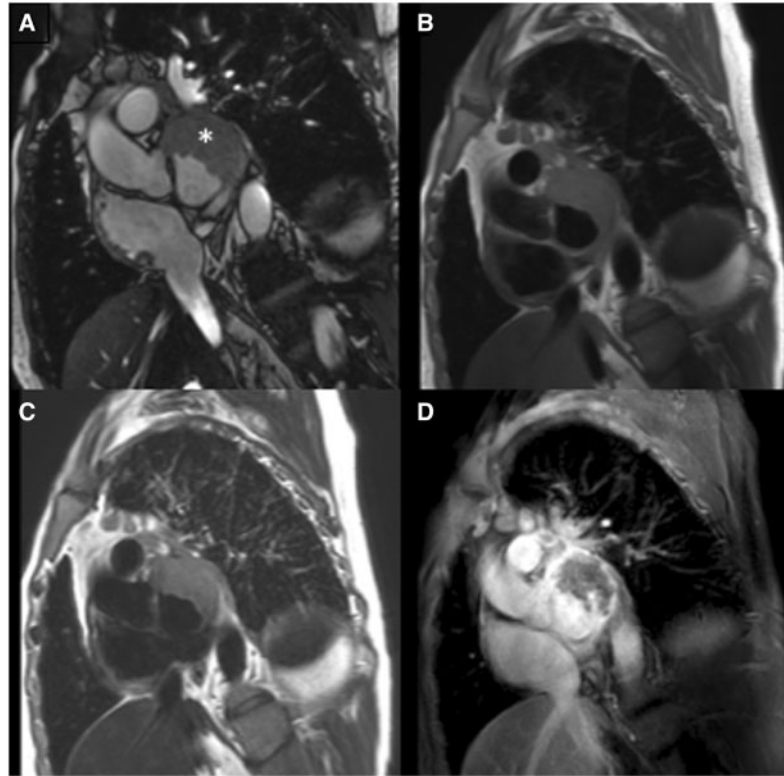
Cardiac magnetic resonance imaging demonstrating solitary left atrial tumour (asterisk) with exophytic protrusion into atrial lumen, shown on cine-sequence (A). Homogenous isointense signal in T1- (B) and T2-weighted sequence (C). (D) Five minutes after gadolinium administration no evidence of considerable contrast-enhancement of atrial mass. No increased perfusion compared with myocardium.
